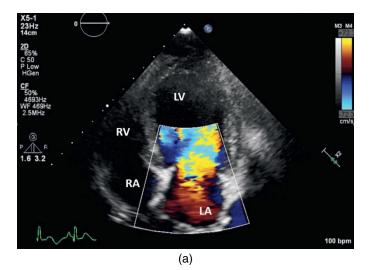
The right parasternal 4 chamber view can be used to evaluate MV flow. (a) During diastole there is typically red flow moving into the left ventricle. (b) During systole there should be no color flow signals on the atrial side of the closed valve.
